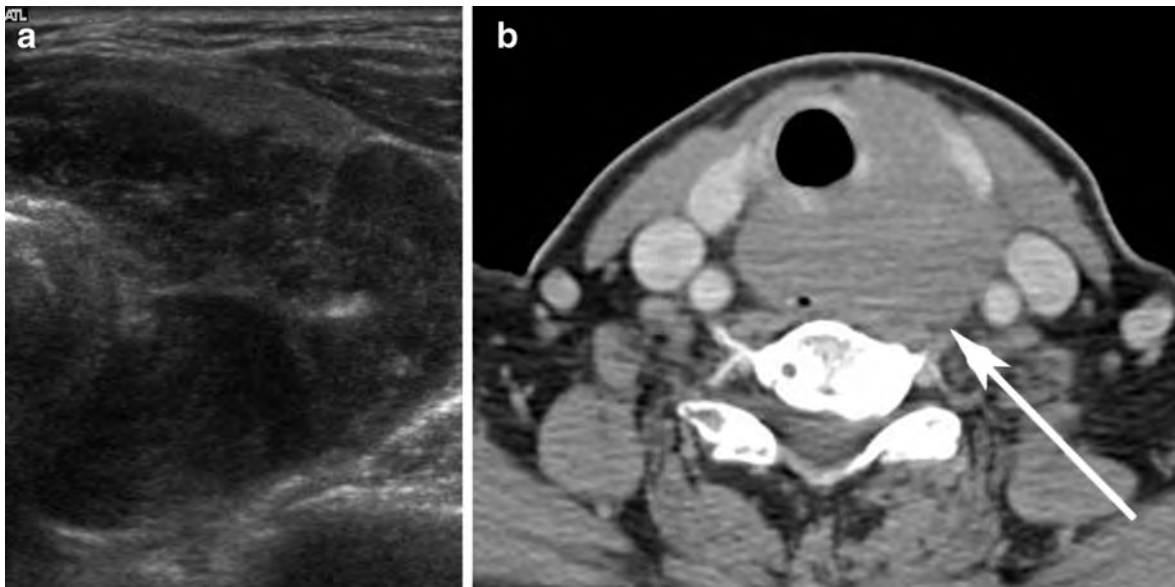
Transverse thyroid US of a hypoechoic mass with posterior extracapsular spread extending into the retrotracheal region (a). Axial contrast-enhanced CT of the same patient
